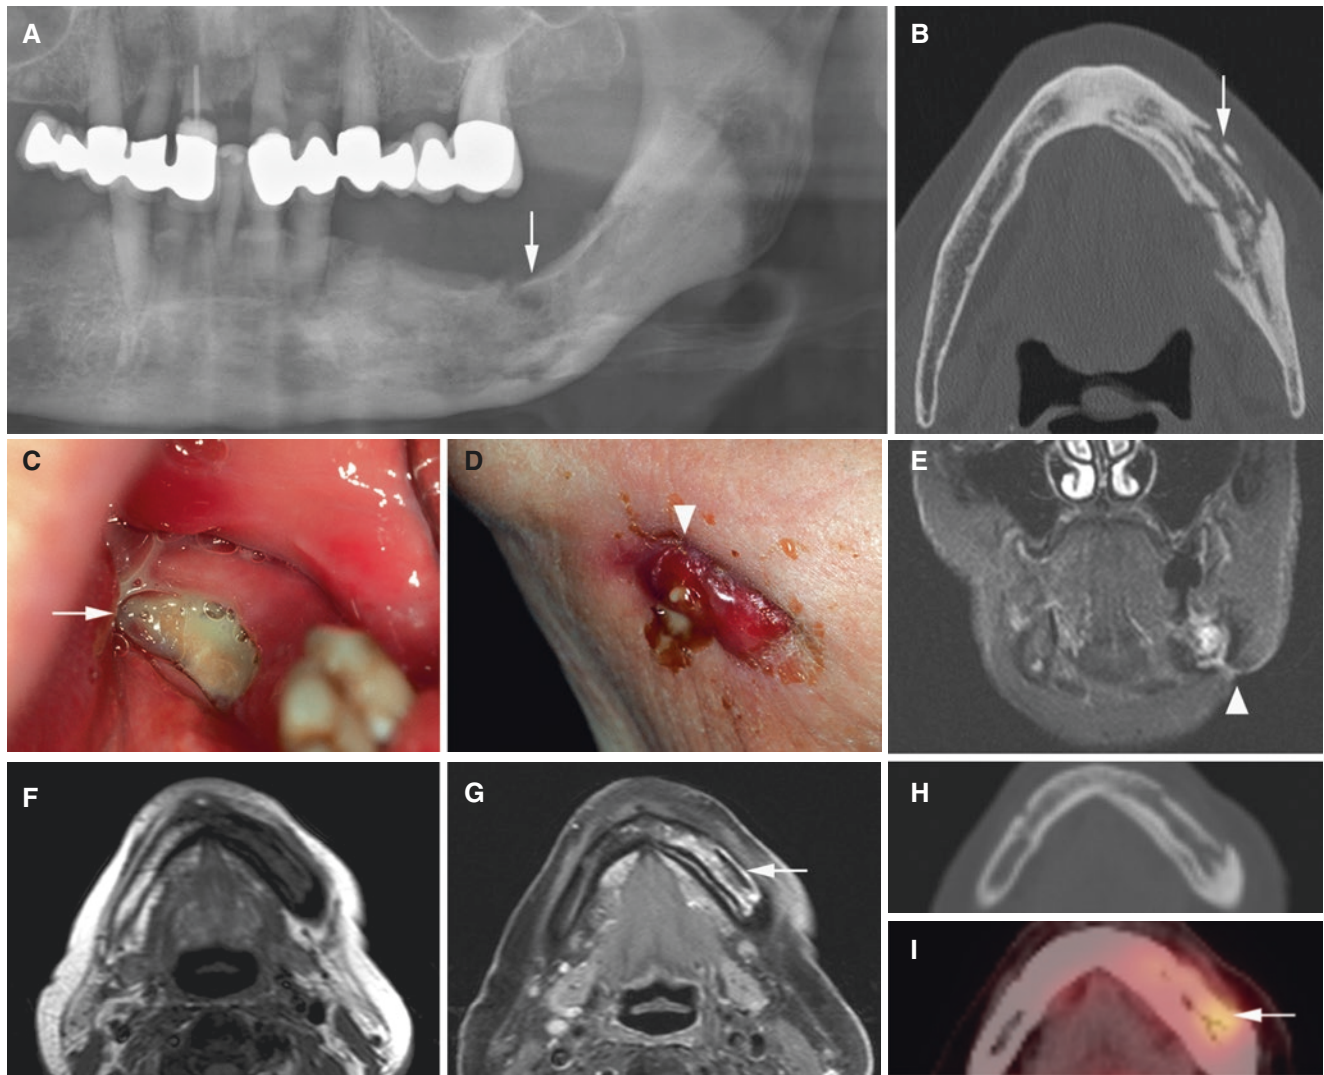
Medication-related osteonecrosis, mandible, with pathological fracture and fistula; 64-year-old female (breast cancer and skeletal metastases, under antiresorptive therapy) with exposed bone and fistula to the skin in the left mandible. (A) Panoramic view shows irregular radiolucent area in left mandibular body, indicating pathologic fracture (*arrow*). (B) Axial CT image shows severe destruction with sequestration (*arrow*). (C, D) Clinical photographs show exposed bone (*arrow*)
